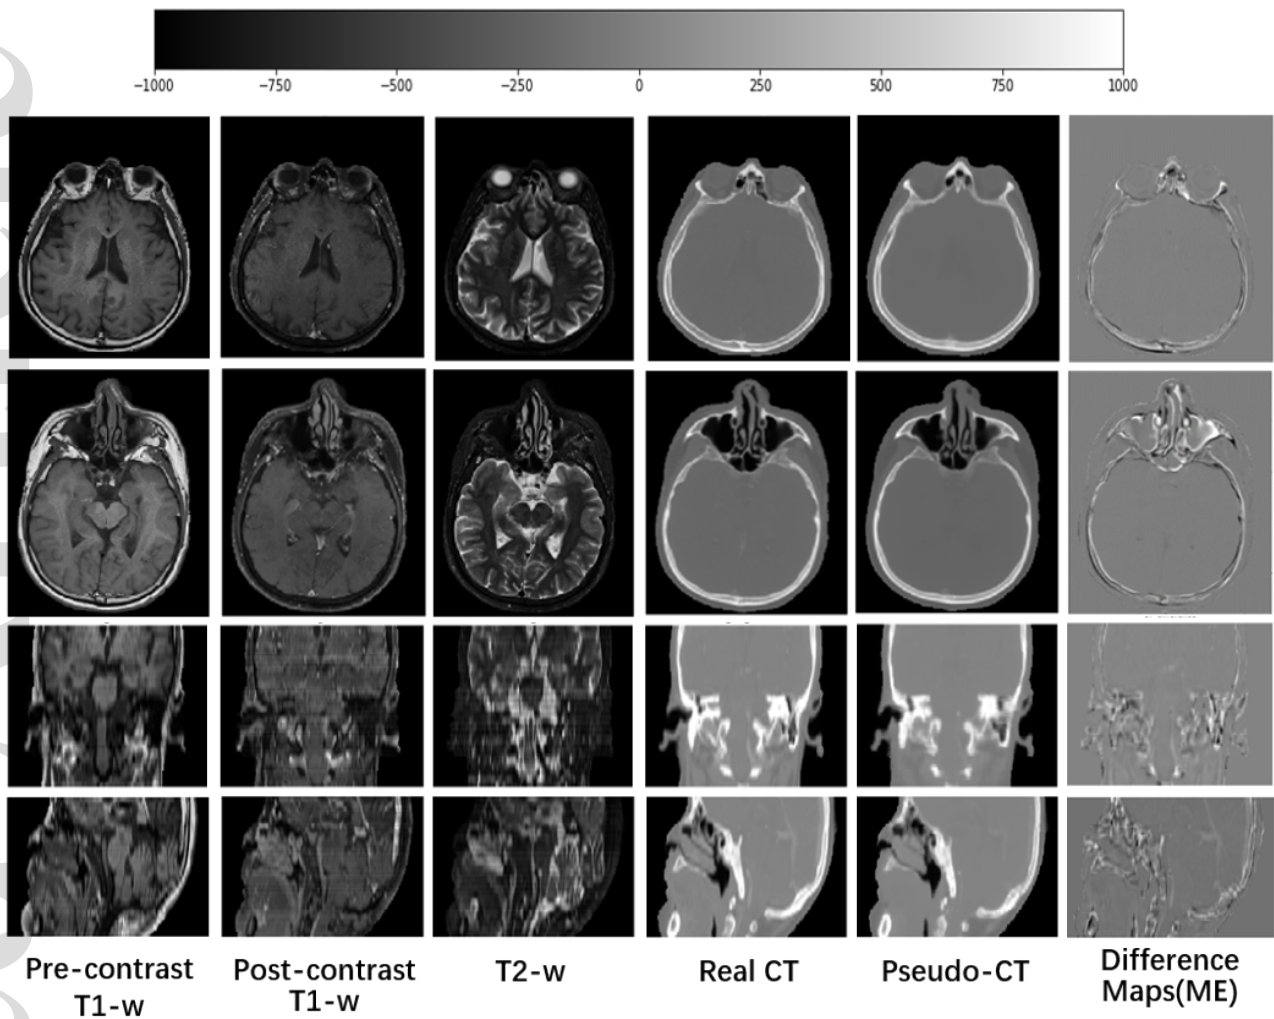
Axial, coronal and sagittal view of the representative pseudo-CT images. Each one is accompanied with the real CT, corresponding MRIs and difference maps. The image types that each column represents have been indicated at the bottom of the figure.
